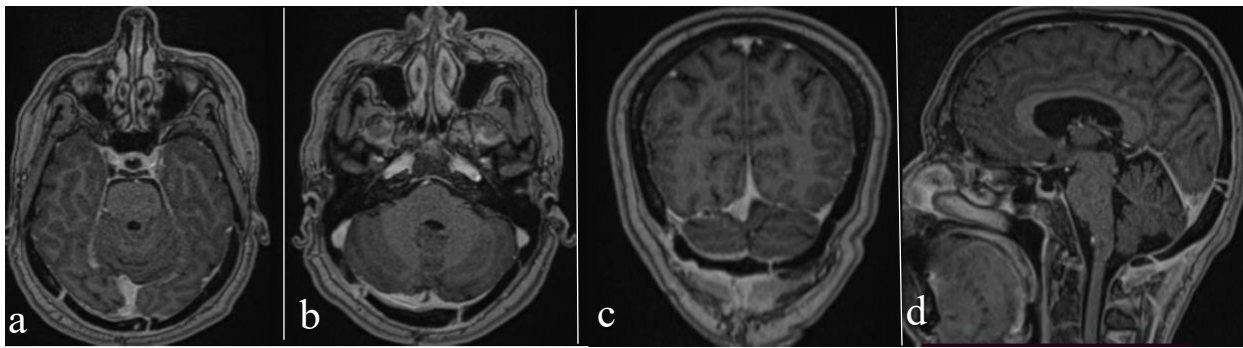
post-surgery MRI after GTR of the lesion in T1-gadolinium sequence: (a+b) axial view, (c) coronal view, (d) sagittal view
